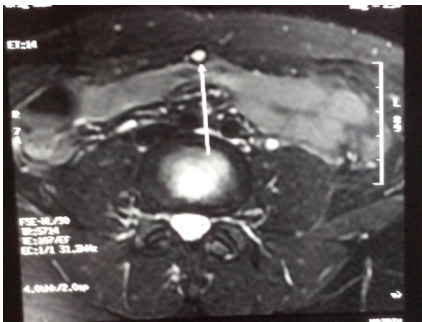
MRI showing sinus tract between umbilicus and urinary bladder
